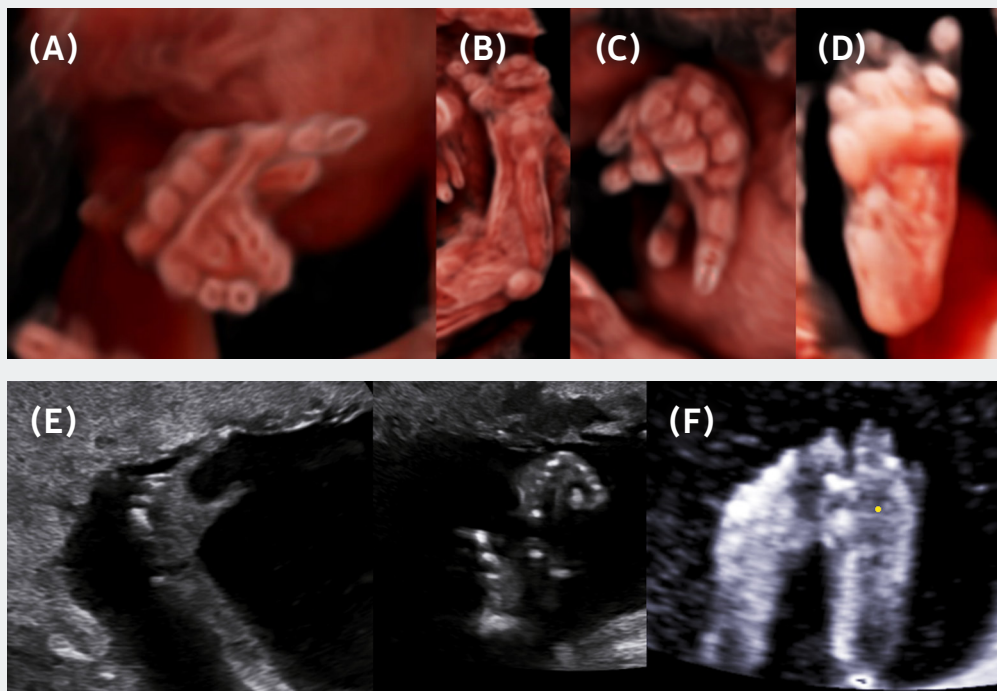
CrystalVue™ rendering: malformations of the fingers and toes (A-D) compared with 2D ultrasound (E-F)
